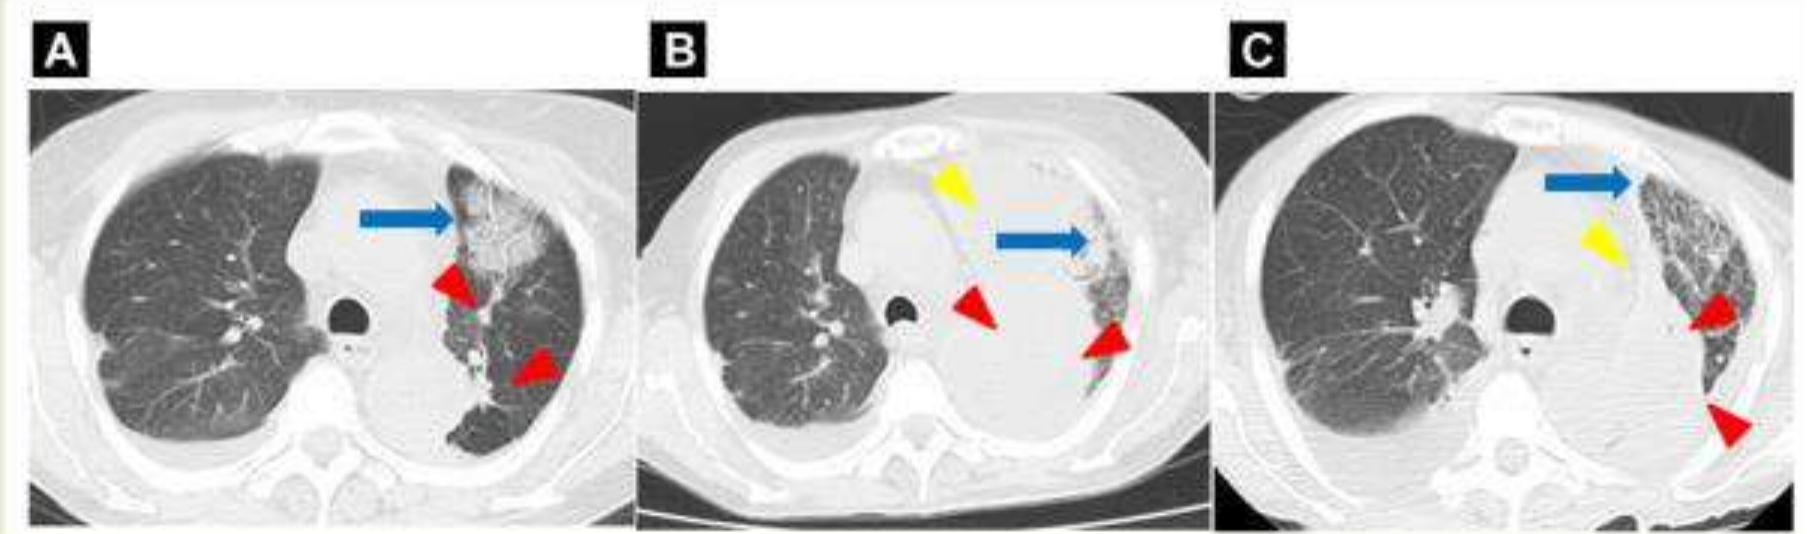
(A) Forty-Five Days After Restarting Crizotinib, Chest Computed Tomography (CT) Showed Crizotinib-Induced Interstitial Lung Disease (ILD) in the Left Upper Lobe of the Lung (Blue Arrow). (B) Four Weeks After Cessation of Crizotinib, Chest CT Showed That the Tumor had Expanded Dramatically, Which Seems to be a Disease Flare, and ILD Remained (Blue Arrow). (C) Chest CT Revealed no Exacerbation of Crizotinib-Induced ILD in the Left Upper Lobe of the Lung (Blue Arrow), Although the Anterior Part of the Tumor Shrank (Yellow Arrowhead) and the Posterior Part of the Tumor did not Regrow (Red Arrowhead), Resulting in Stable Disease According to Response Evaluation Criteria in Solid Tumors
